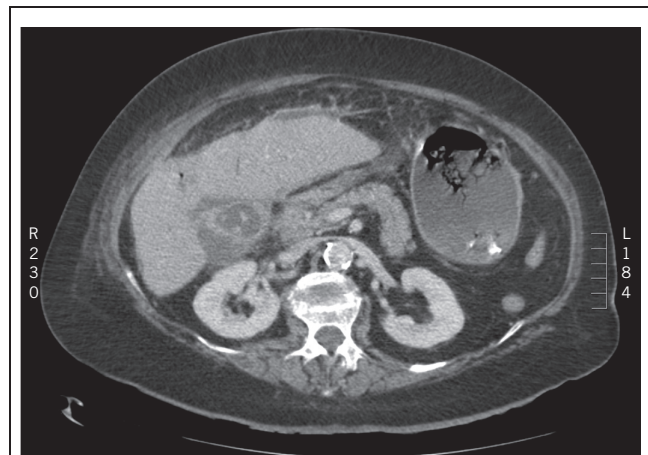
Computed tomography image showing a 7 × 7cm sub-hepatic abscess containing gallstones.
